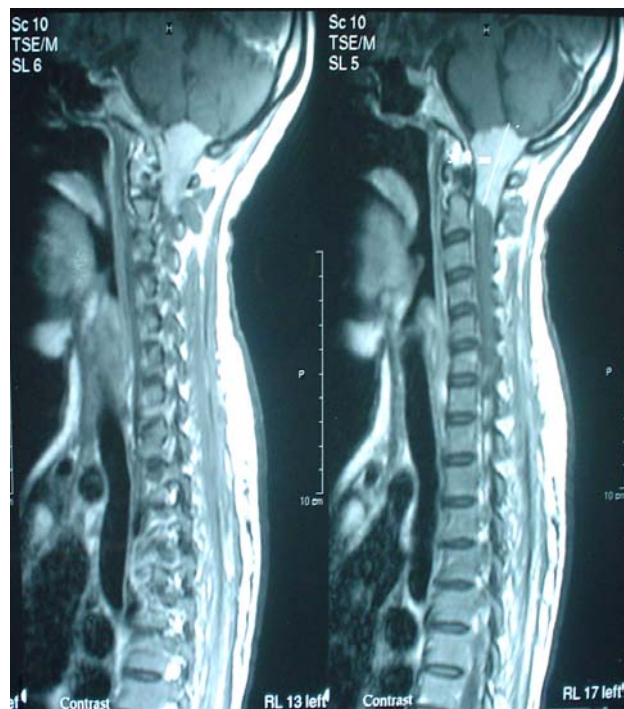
Sagittal MRI section showing tumor with meningeal tail, extending into posterior fossa and caudally to level of C3
